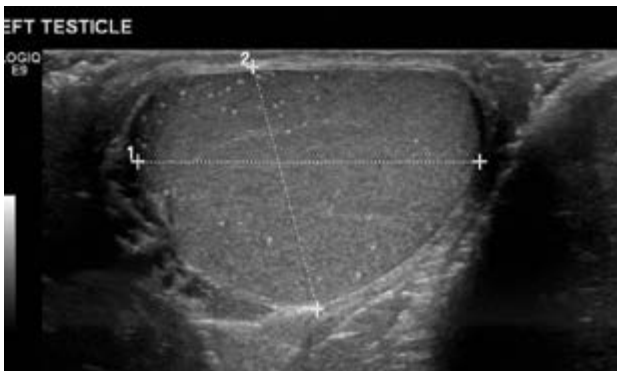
Microlithiasis of the left testis in a 31 - year old man with a history of right orchietomy due to a seminoma. Scrotal ultrasound, longitudinal section
